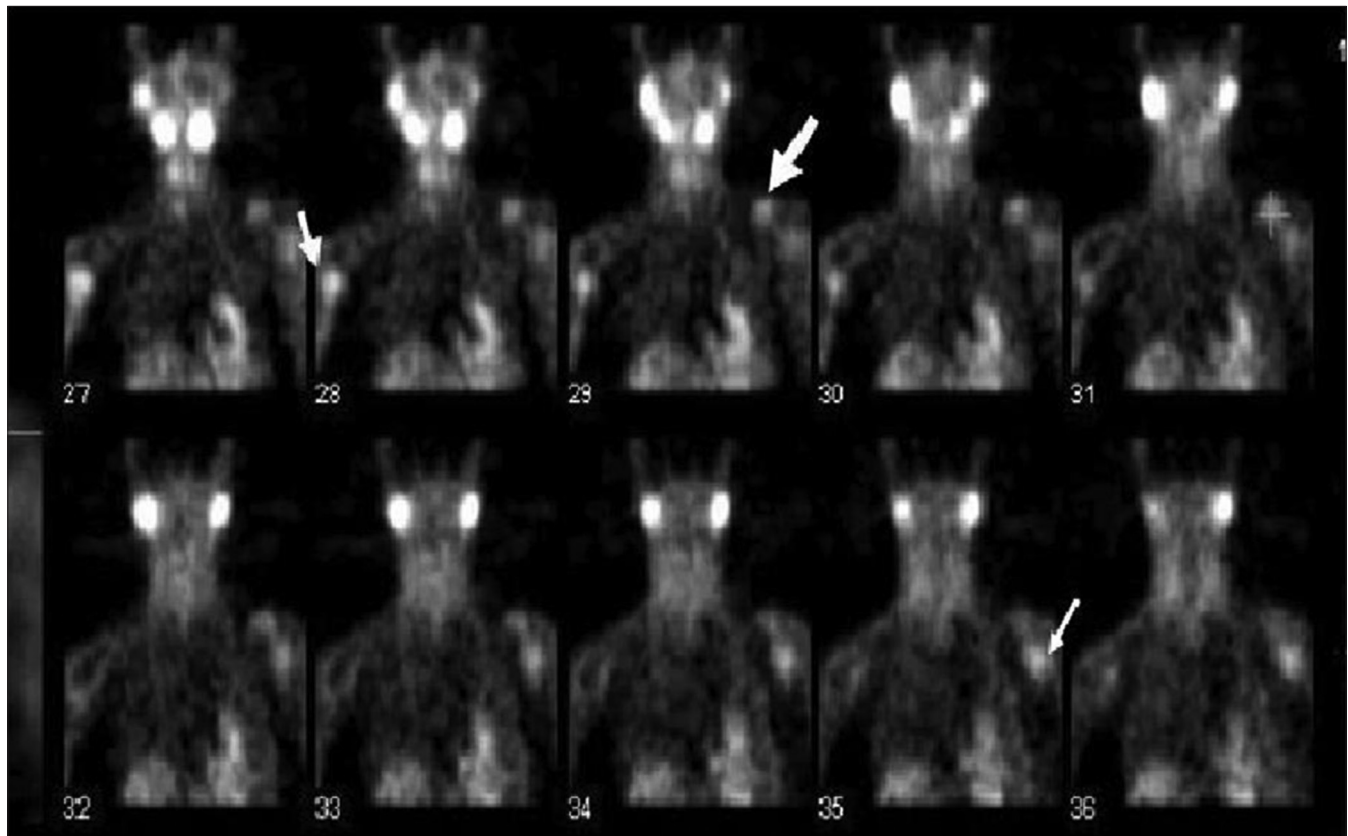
99mTc-Sestamibi SPECT images, coronal view: Foci of abnormal tracer uptake in the proximal half of left humerus, head of right humerus, and left clavicle (thick arrow)
